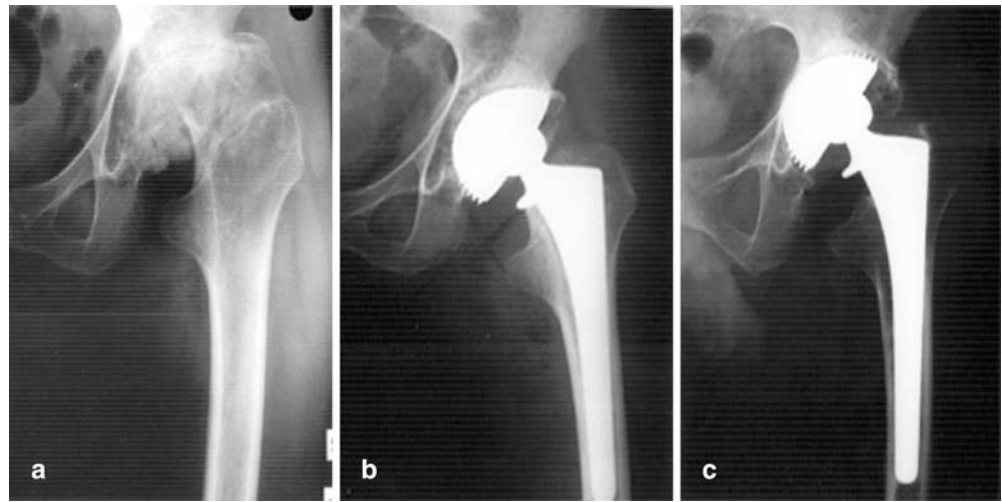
a Post-operative hip radiograph of a juvenile chronic arthritis (JCA) patient at the age of 16 years after cementless replacement with Bi-Metric stem and Romanus cup (Hexloc fixation). b Same hip 8 years post-operatively showing severe wear of the liner
